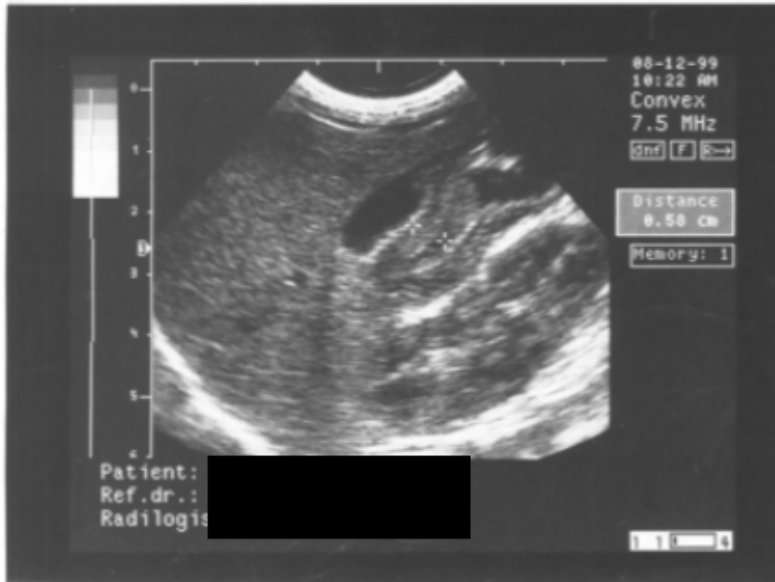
Ultrasound appearances of pyloric stenosis
